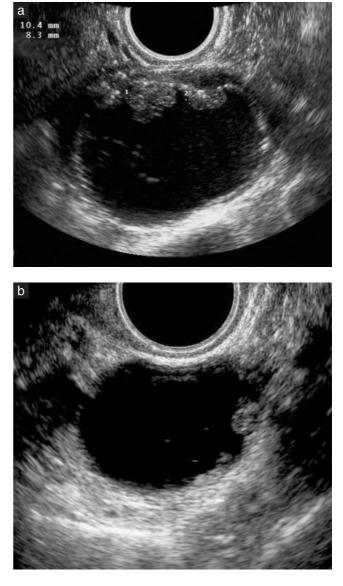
Ultrasound images comparing a serous papillary borderline ovarian tumor in a 48-year-old patient (a) with a benign serous papillary cystadenoma in a 52-year-old patient (b) showing the similar sonographic features: cyst with small papillae.
